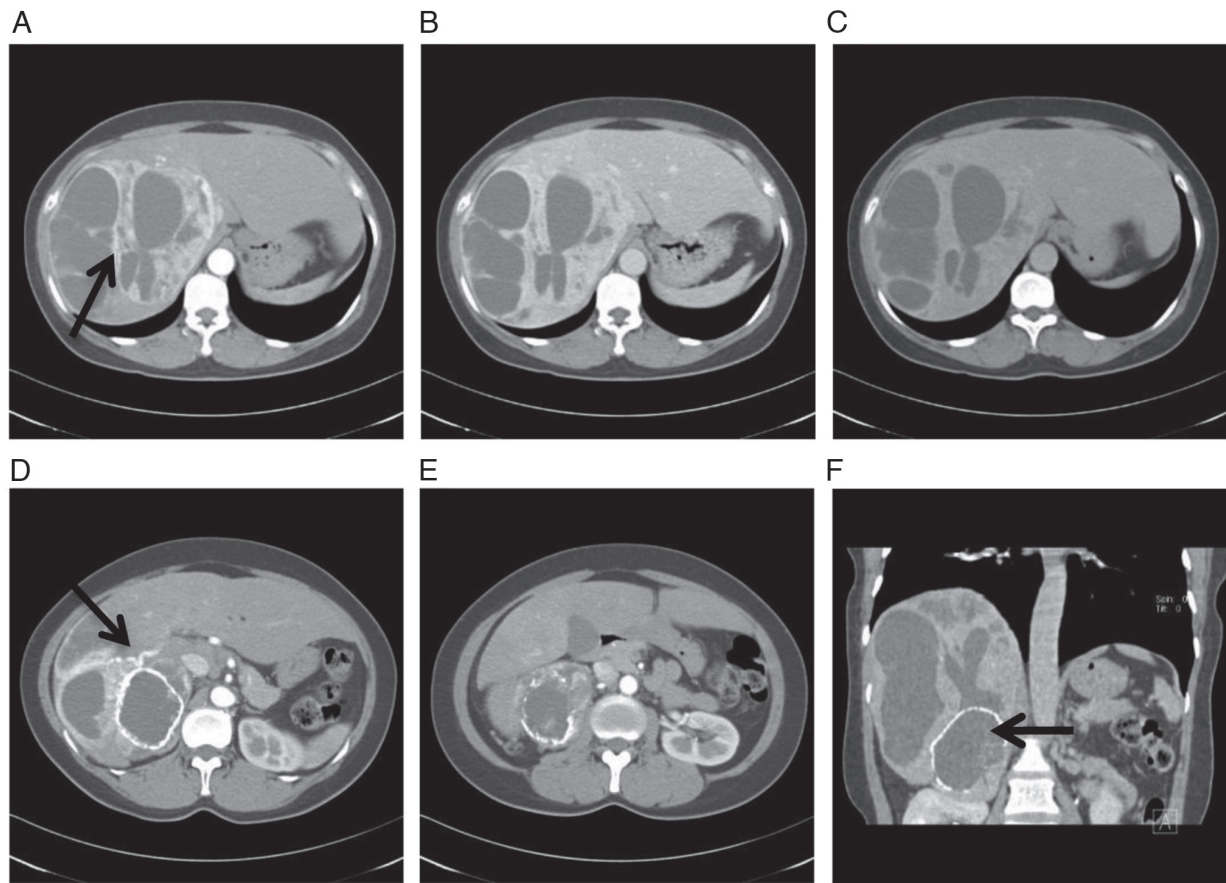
CT enhanced images of the upper abdomen at diagnosis. (A) CT image of arterial phase. A huge cystic solid mass was observed in the right lobe of the liver, with an obvious enhancement of solid parts and separations but no enhancement in the cystic area (black arrow). (B) CT image of portal venous phase. There was continuous enhancement of the mass. (C) CT image of delayed phase. The density of the mass was similar to that of liver tissue. (D) The right hepatic artery was enlarged, providing blood to the mass (black arrow). (E) The density of the mass in the right adrenal gland was uneven, with annular calcification. After enhancement, the solid part was obviously enhanced, but the cystic area was not enhanced. (F) The coronal image clearly showed the positional relationship between the liver and adrenal masses and the adrenal tumors on the right side were surrounded by circular calcifications (black arrow).
